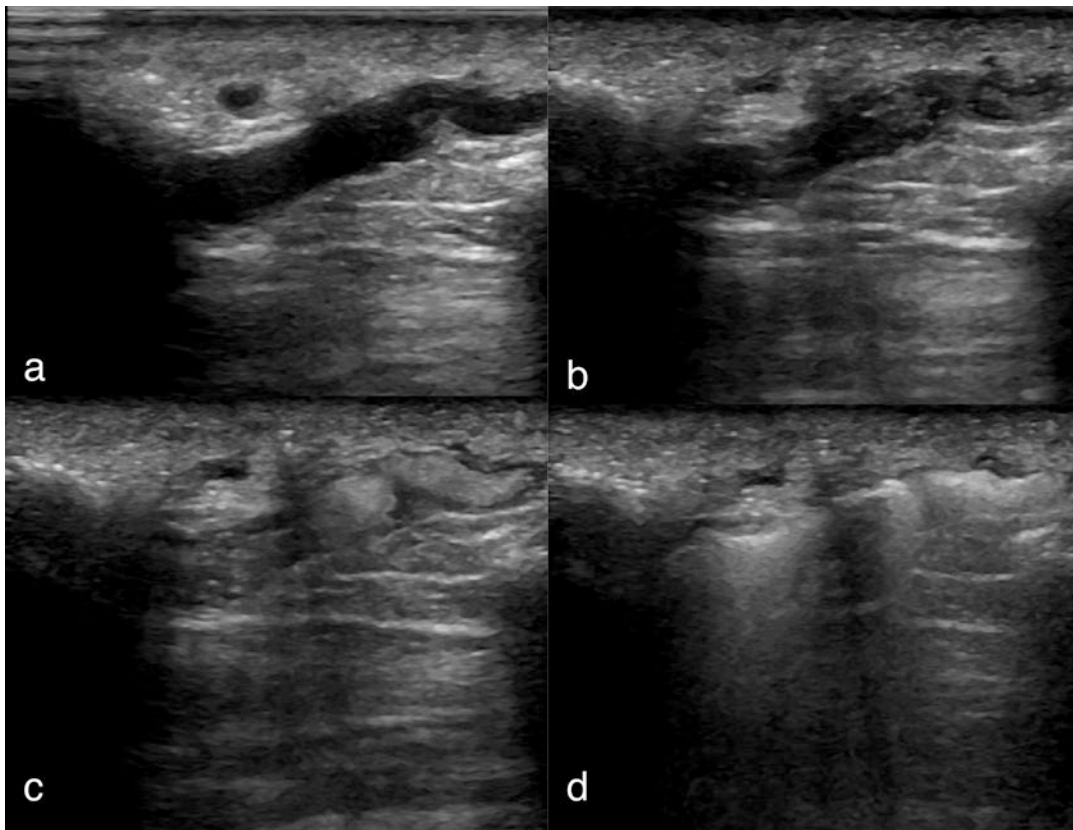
Ultrasound-guided foam sclerotherapy of a perforator vein. (a) Perforator vein prior to injection. (b) Visualization of the sclerosant within the vein. (c) Partial
